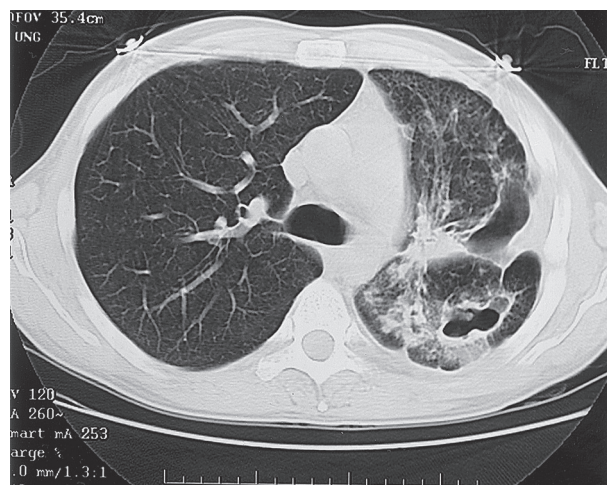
■ Computed tomography scan showing severe cavitory disease in a patient with *Mycobacterium chelonae* infection.
